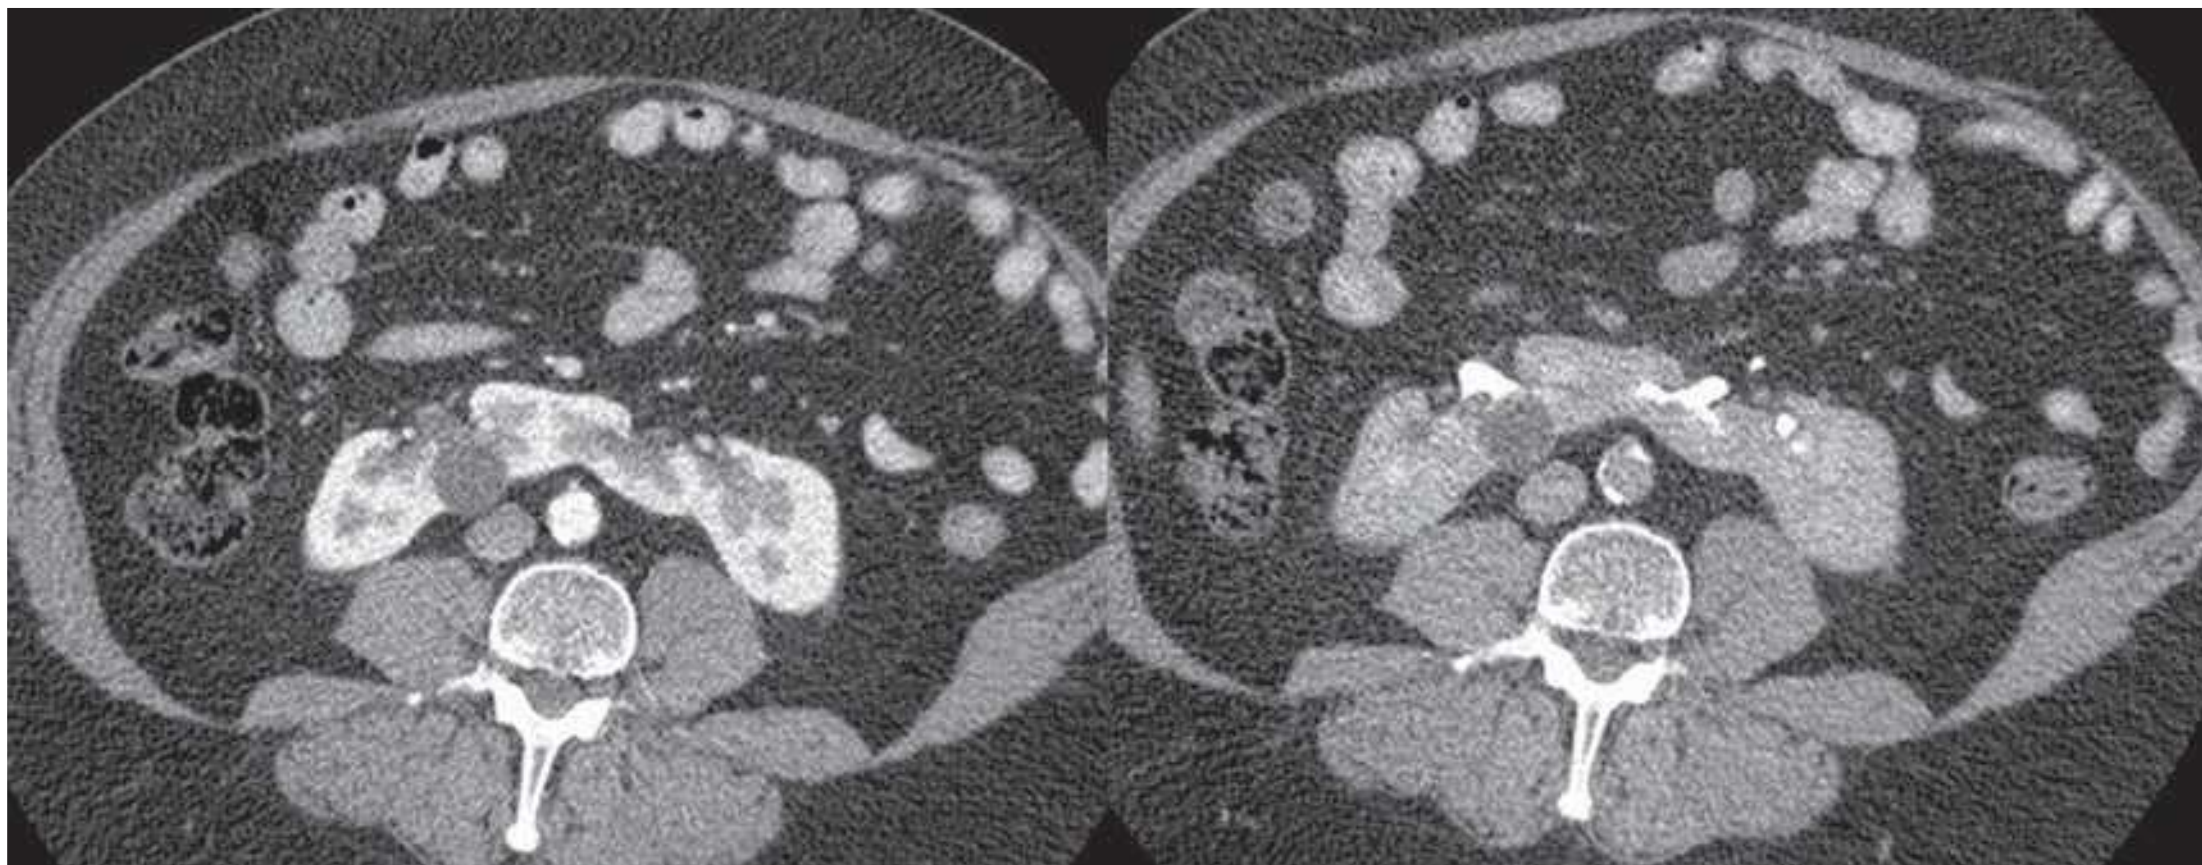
CT images of horseshoe kidney obtained at corticomedullary (*left*) and delayed excretory phase (*right*). A small cyst is noted in the right kidney.
